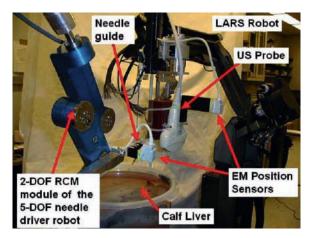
Close-up of biopsy experiment; a robot (the IBM/JHU LARS) holds the ultrasound probe and a second robot is used for positioning a needle guide. On both, an electromagnetic (EM) tracking system (Flock of Birds, model 6D FOB, Ascension Technology, Inc.) interfaces with the robot workstation. [Reprinted with permission from BOCTOR et al. (2004)]
